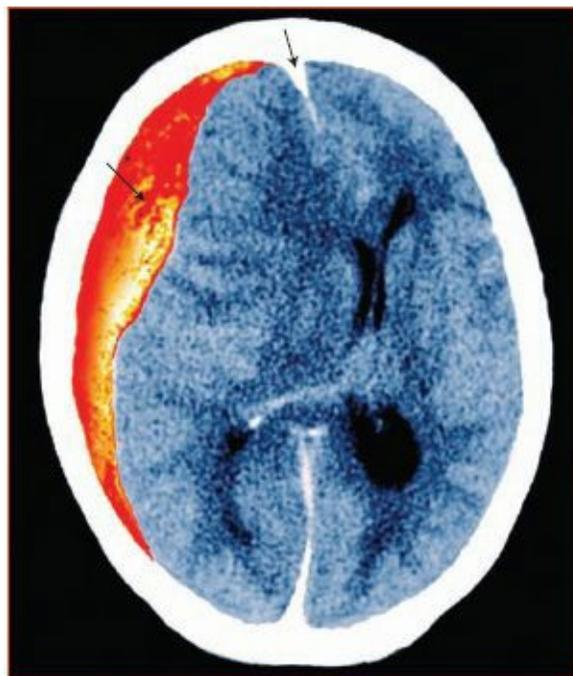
A computed tomography scan showing a head bleed with a midline shift.
